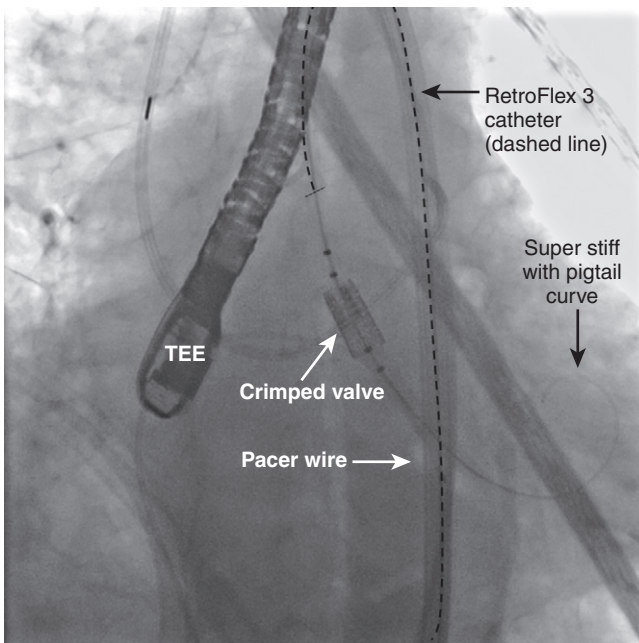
Fluoroscopic view before valve deployment. Transesophageal echocardiogram (TEE) is used adjunctively for proper positioning. A pacer wire is present in the right ventricle for rapid pacing. A super stiff guidewire with a pigtail curve resides in the left ventricle. The RetroFlex catheter is retracted back to fully expose the delivery balloon. A pigtail catheter (behind the TEE probe) is also present, which was used to perform supra-avalvular aortography.
